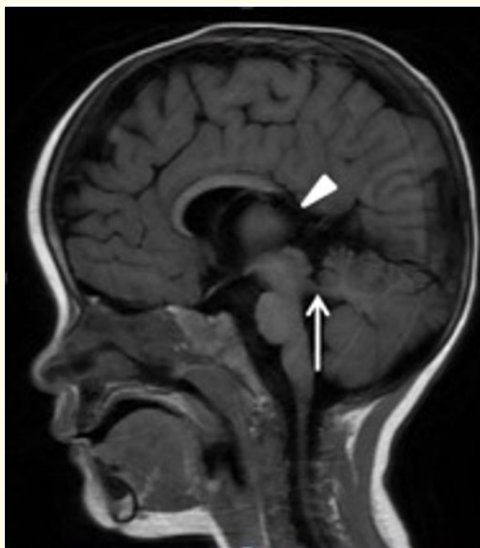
T1-weighted parasagittal image showing a horizontally oriented superior cerebellar peduncle (white arrow) and partially agenesis of splenium corpus callosum (white triangle).
